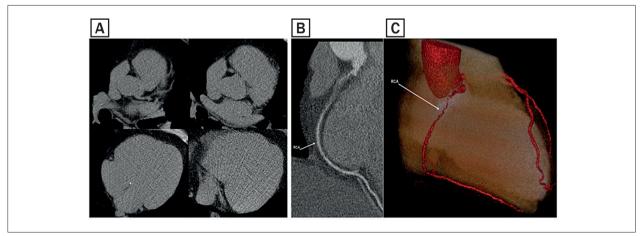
Coronary calcium scoring and cardiac computed tomography angiography in a CORE participant with significant coronary obstruction and calcium score zero. A) Coronary calcium scoring. B) Cardiac computed tomography angiography (multiplanar reconstruction). C) Cardiac computed tomography angiography (3D reconstruction).
